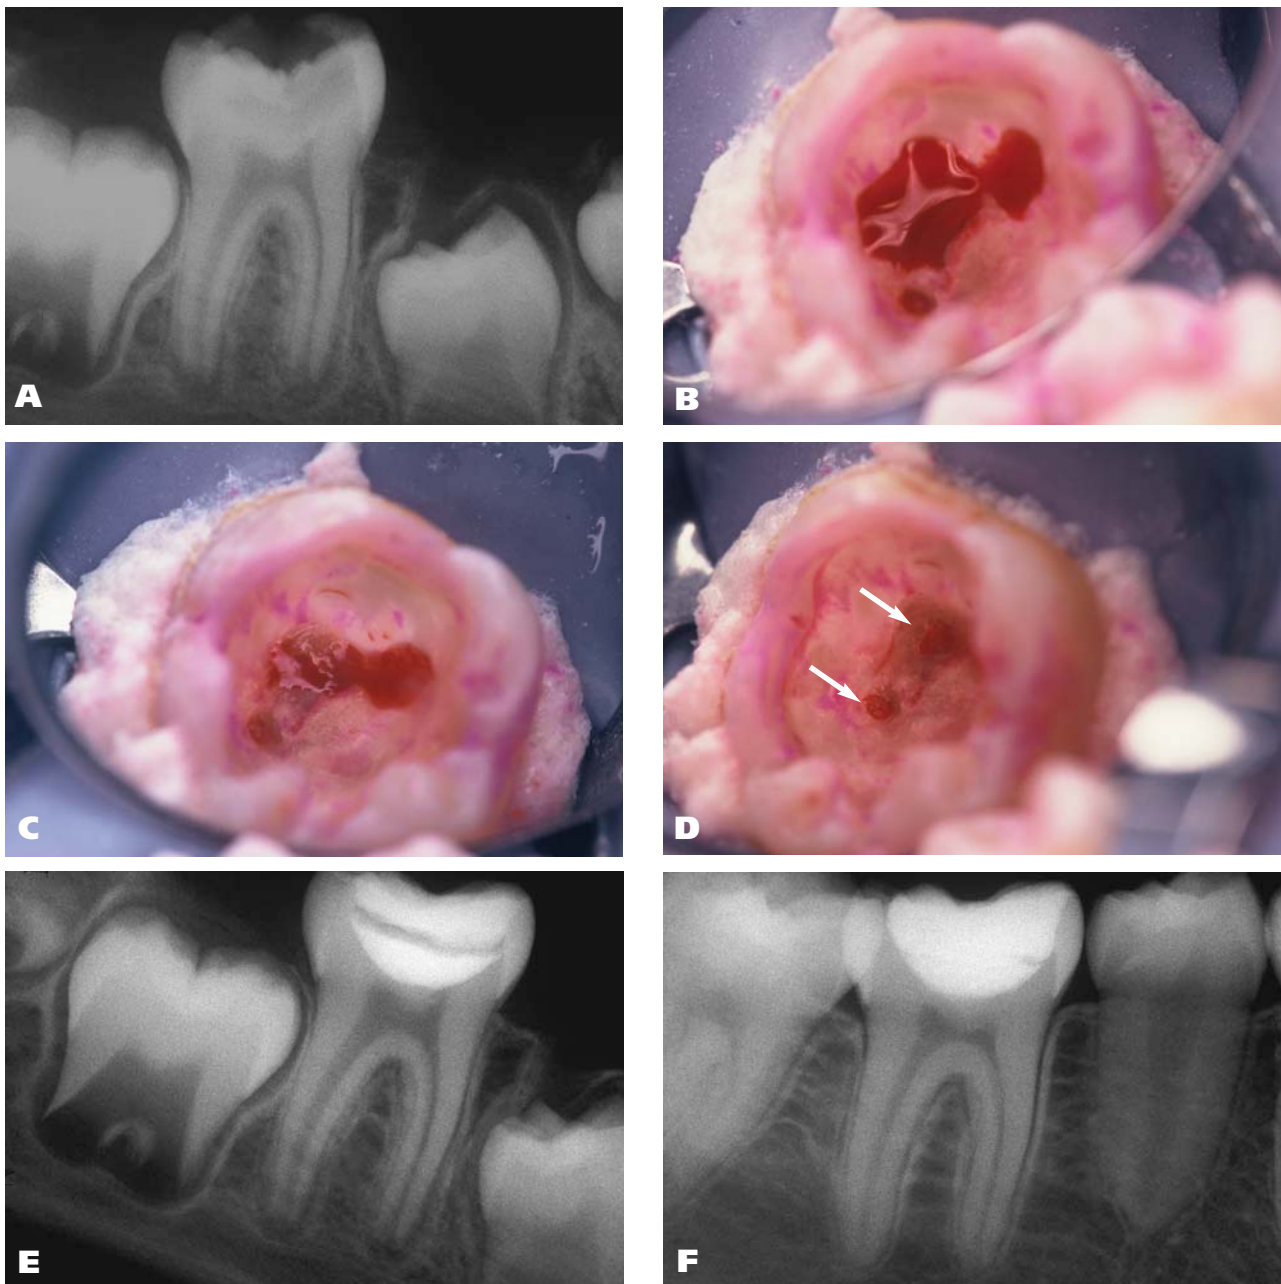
Radiographic and clinical sequence of mineral trioxide aggregate (MTA) direct pulp capping of a mandibular right molar in a 9-year-old female patient. A. Pretreatment radiograph showing initial deep caries and immature apices. B,C,D. Five-minute time of 5.25 percent sodium hypochlorite hemostasis, on two 1.5- to 2.0-millimeter exposures (arrows). E. Radiograph of molar with MTA, water-moistened cotton pellet and unbonded Clearfil Photocore (Kuraray Medical, Okayama, Japan) provisional restoration after initial visit. F. Radiograph taken at the 5.5-year recall appointment showing permanent restoration and evidence of complete root formation. The tooth exhibited a normal response to cold testing.
